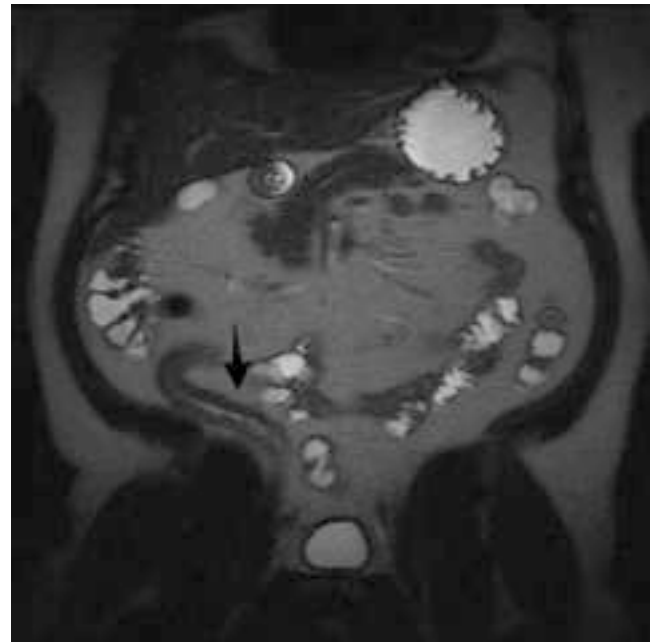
MRE in Crohn's disease. Coronal T2-weighted images demonstrate segmental mural thickening of the terminal ileum (black arrow).
